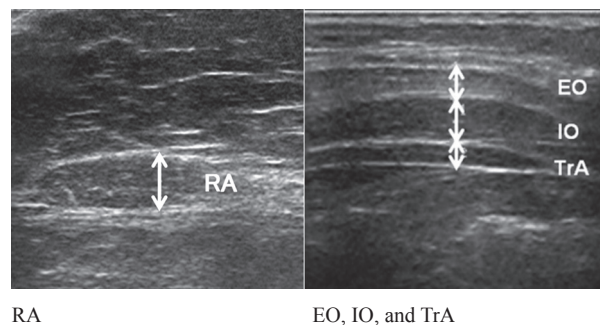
Ultrasound imaging of rectus abdominis (RA), external oblique (EO), internal oblique (IO), and transversus abdominis (TrA). The transducer was held perpendicular to the skin surface using the minimum pressure required to achieve a clear image. We drew a vertical line, and measured the thickness of each muscle using on-screen calipers.
